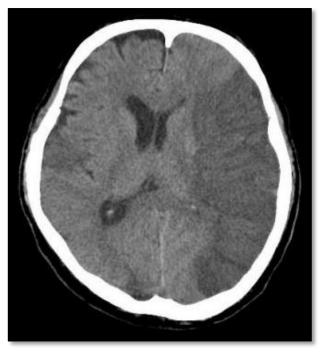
Vascular distributions: Middle cerebral artery (MCA) infarction. Noncontrast computed tomography (CT) scanning demonstrates a large acute infarction in the MCA territory involving the lateral surfaces of the left frontal, parietal, and temporal lobes, as well as the left insular and subinsular regions, with mass effect and rightward midline shift. There is sparing of the caudate head and at least part of the lentiform nucleus and internal capsule, which receive blood supply from the lateral lenticulostriate branches of the M1 segment of the MCA. Note the lack of involvement of the medial frontal lobe (anterior cerebral artery [ACA] territory), thalami, and paramedian occipital lobe (posterior cerebral artery [PCA] territory) (Ashrafian, 2010).
